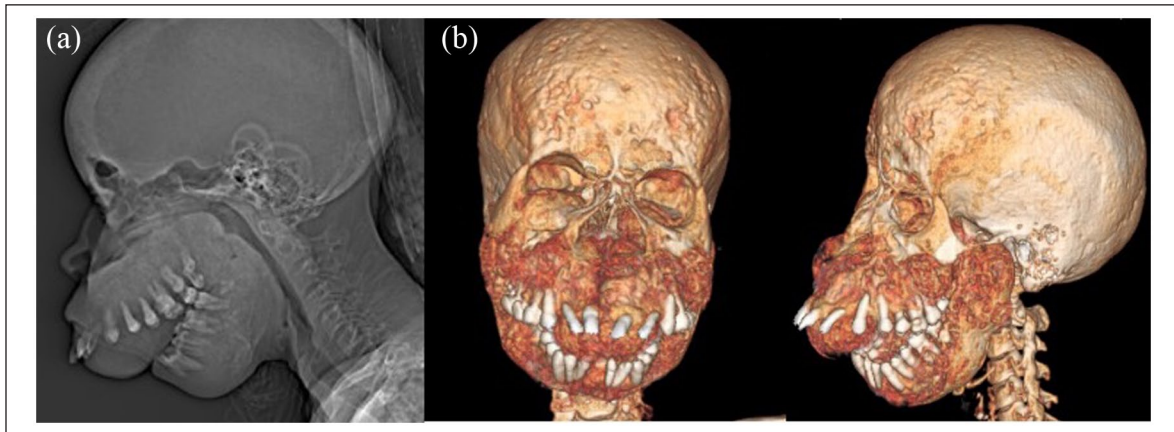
Side profile plain x-ray of the face (a) showing a massive hypertrophy of maxilla and mandibular bones showing a sclerotic aspect. Volume rendering CT scan of the face and skull (b) showing facial disfiguration with a massive hypertrophy and heterogenous aspect of both maxilla and mandibular bones corresponding to the brown tumors of the jaw.
